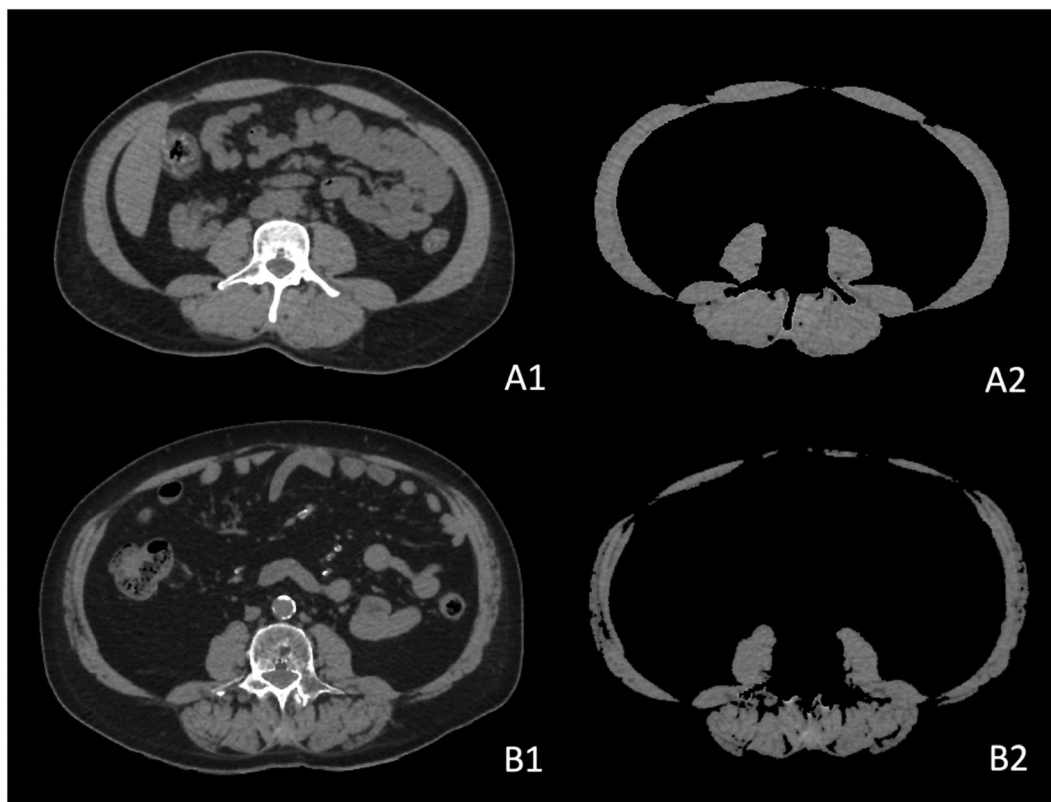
Unenhanced computed tomography scan taken at the level of the middle of the third lumbar vertebra, for two male kidney transplant recipients (A and B) before (A1 and B1) and after (A2 and B2) the segmentation of total lumbar muscle cross-sectional area. The two patients have similar skeletal muscle index: $50.4 \text{ cm}^2/\text{m}^2$ for Patient A and $54.3 \text{ cm}^2/\text{m}^2$ for Patient B. In contrast, their muscle densities are different: Patient A has a normal muscle density (43.8 HU), whereas Patient B is considered to have myosteatosis (21.3 HU) according to our criteria.
